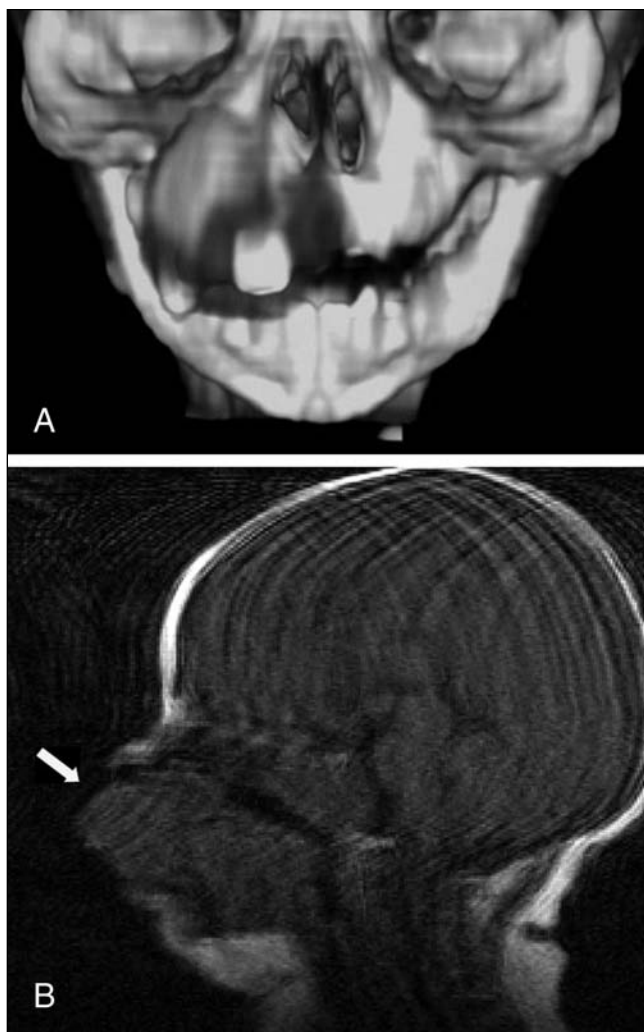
A Preoperative three-dimensional computed tomography scan showing an extensive tumour involving the maxilla and orbital floor. B Sagittal magnetic resonance imaging demonstrating depth of tumour invasion. Arrow shows anterior extent of tumour
